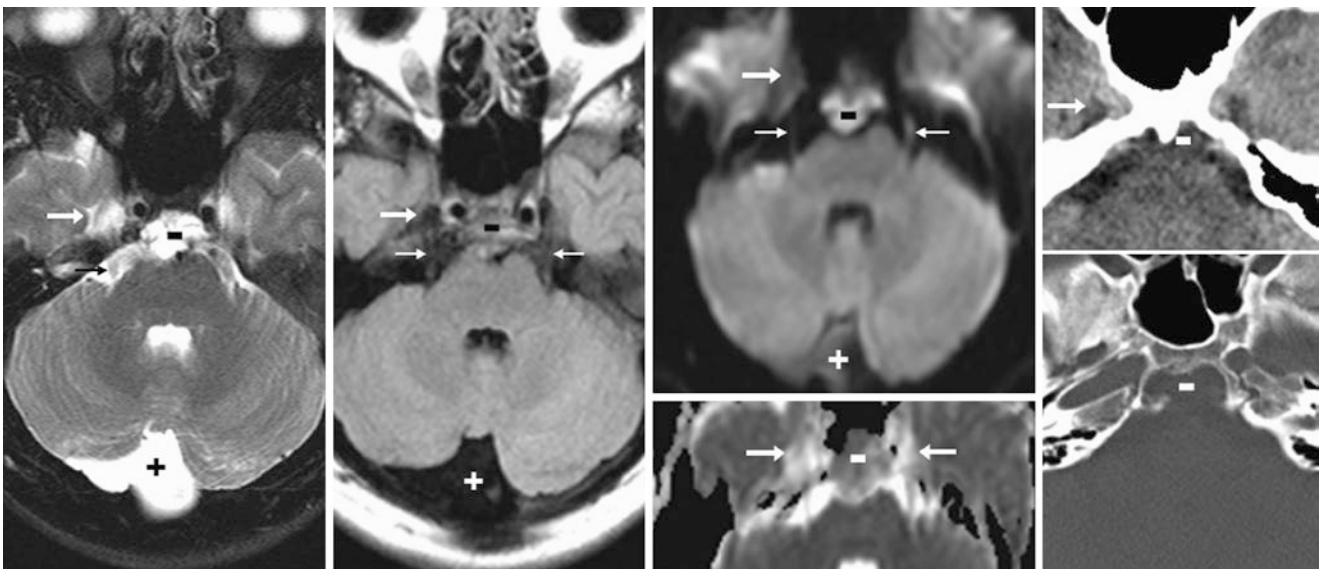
Comparison case of epidermoid cyst. A 20-year-old patient with 1.5 T MRI axial T2WI (*left*) and FLAIR (*left middle*) had an normal incidental enlarged right Meckel cave (*arrows*). A T2- and FLAIR-bright lesion (–) was also noted within the clivus and prepon-tine cistern that did not enhance (*not shown*) that was bright on DWI
